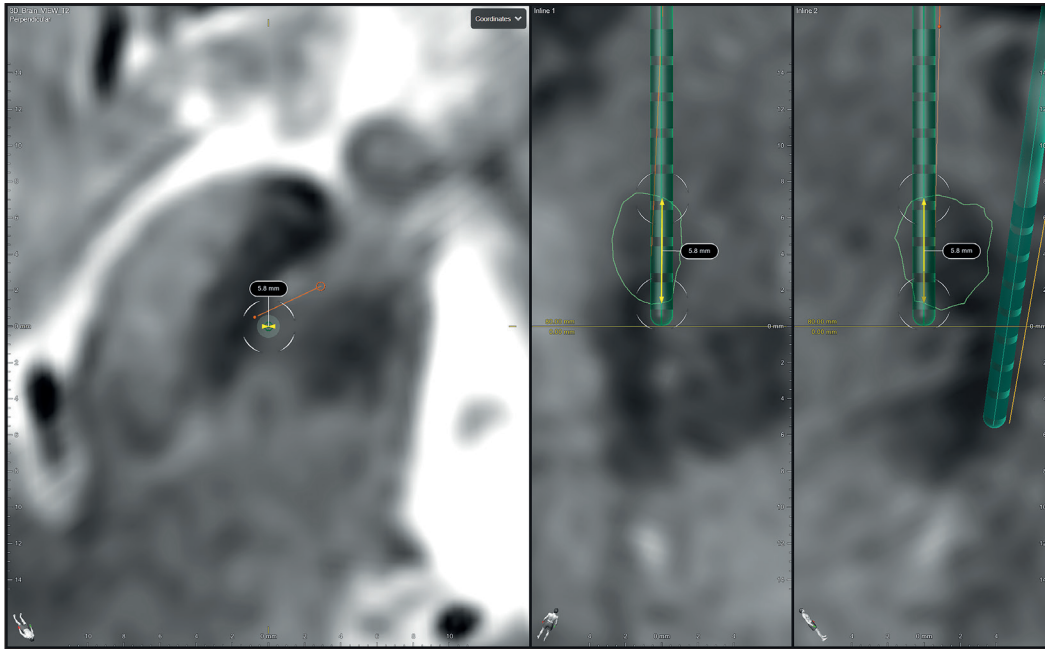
Measurement of the length of the Left STN on the T2 MR image. The lead was modeled in 3D on the postoperative CT. Then, the 3D lead was fused to the T2-weighted image. The image was reconstructed with the lead as the axis. The widest view of the demarcated STN was selected (Green). Finally, the length of the STN was measured along the midline of the lead (Yellow).
